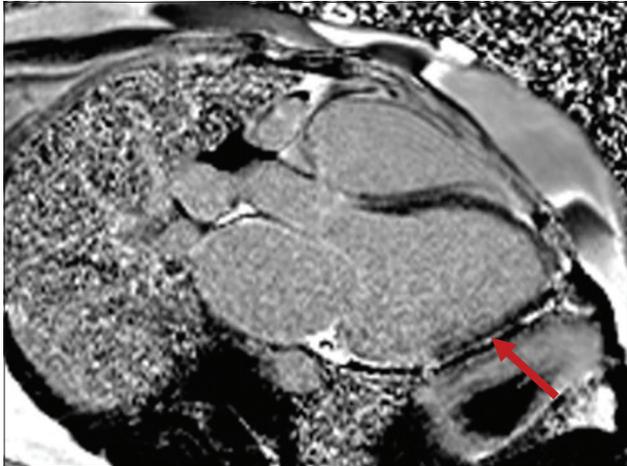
A 27-year-old female presented with shortness of breath and severe left ventricular systolic dysfunction on echocardiogram. Cardiac magnetic resonance steady-state free-precession still frame, 4-chamber view showing dilated left ventricle (arrow).
